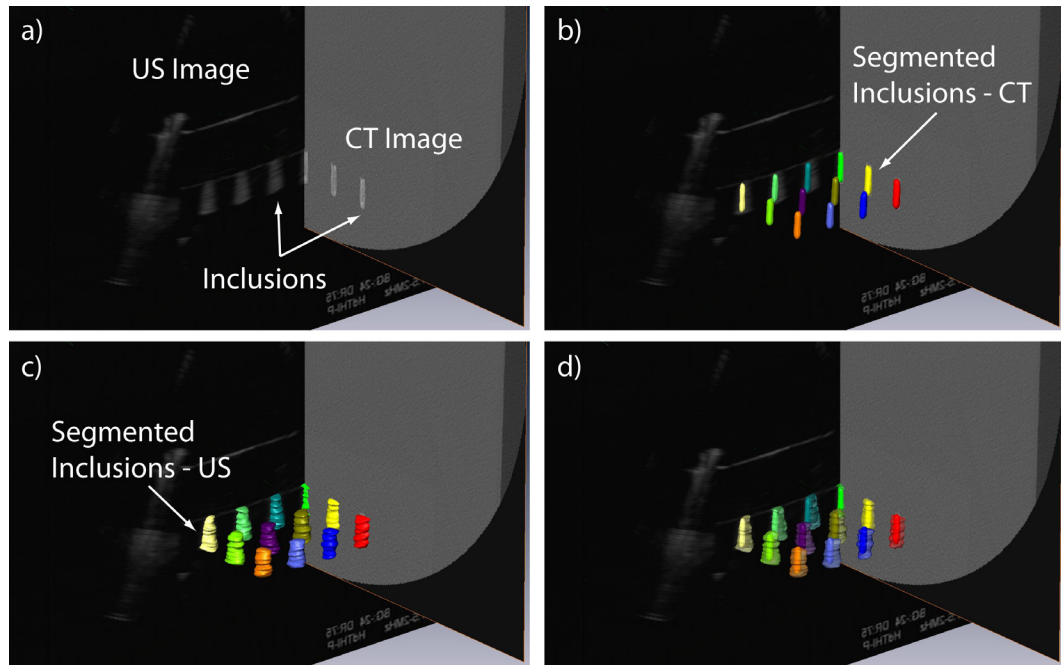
Fused ultrasound and CT images and segmented inclusions
